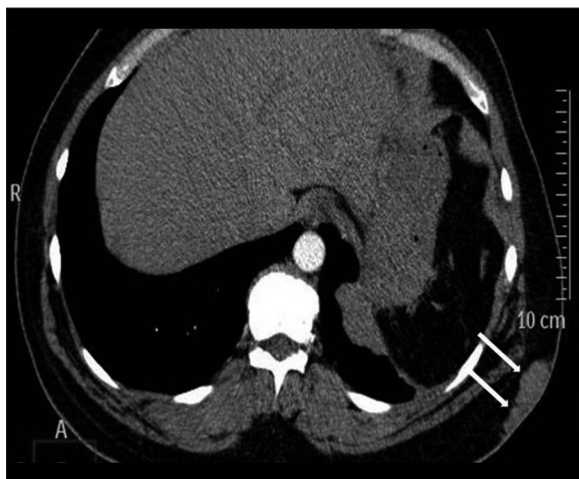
Axial contrast-enhanced CT revealed soft-tissue lesions (arrows) in the subcutaneous tissue of the posterolateral wall of the left hemithorax.
